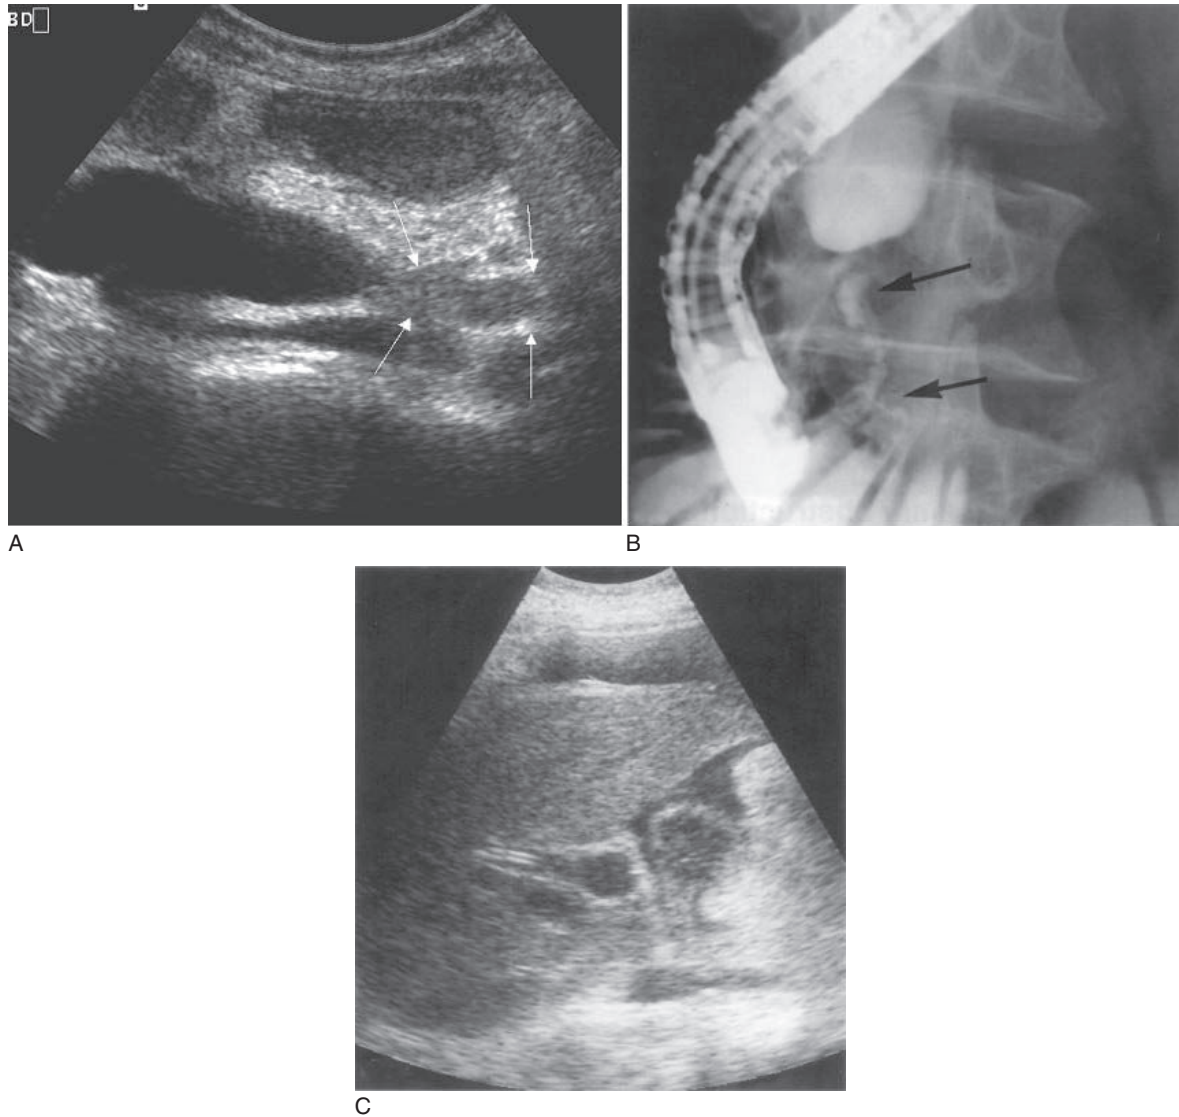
(A) This dilated CBD is obstructed by a mass (*arrows*) invading the lower end. (B) ERCP demonstrates a tight, malignant stricture, and can be used to position a palliative stent. (C) Stent in the CBD of a patient with a cholangiocarcinoma and malignant ascites. Decompression of the dilated biliary tree has been achieved, and ultrasound can be used to monitor the patency of the stent.
